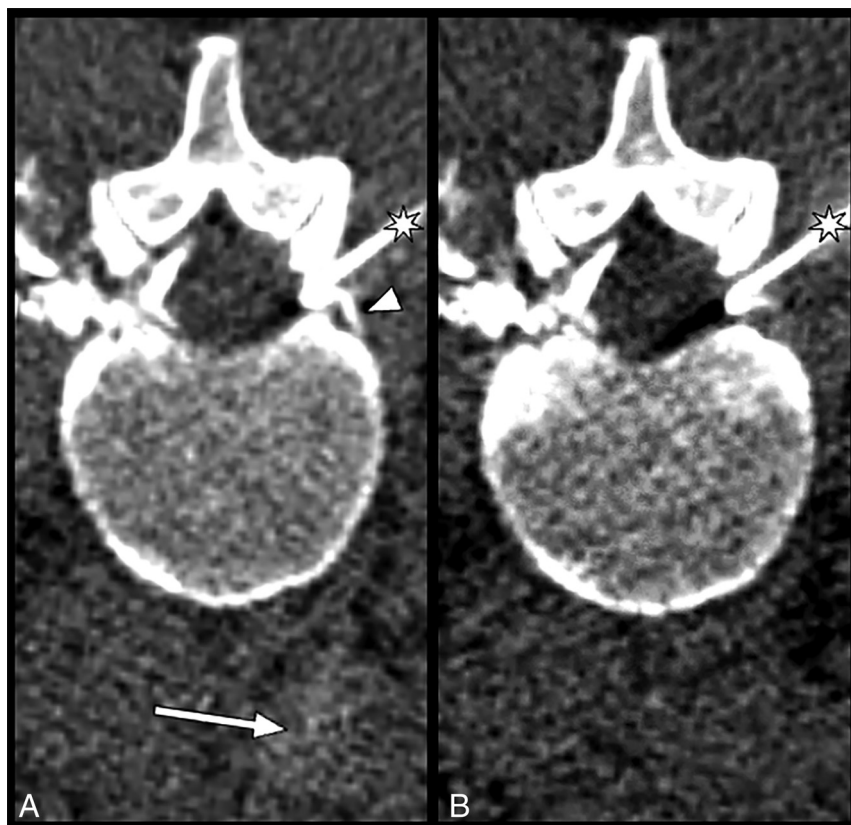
Subtle inadvertent intravenous injection was not recognized during the patching procedure. A 58-year-old woman with an iatrogenic CSF leak secondary to an intrathecal pump placement at L1/2. CT fluoroscopy-guided bilateral transforaminal approach ventral epidural blood and fibrin glue patches were performed. The left side had already been completed. A, Axial CT fluoroscopic image during right posterior oblique approach needle placement (star) during the initial epidurogram with acquisition immediately after contrast media injection. Note that curvilinear contrast extends anterolaterally from the neuroforamen suggesting intravascular injection (arrowhead). There is also a subtle blush of contrast in the inferior vena cava (arrow). B, Subsequent axial CT fluoroscopic image acquired 1–2 seconds later. There is rapid contrast washout in both structures consistent with an inadvertent intravenous injection.
